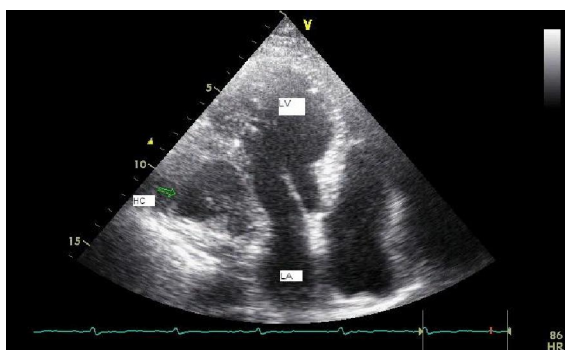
An apical four chamber view of the hydatid cyst (HC), located intramyocardially at the left ventricular lateral wall. LA; left atrium, LV; left ventricle, HC; Hydatid cyst
